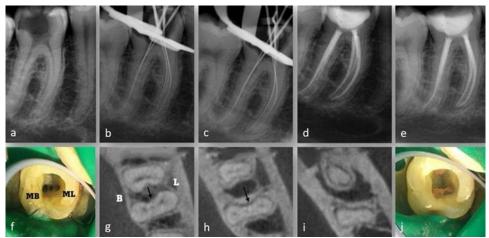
A midmesial canal in a mandibular first molar. (a) initial radiograph, (b,c) working length determination, (d,e) after filling, (f) canal orifices in mesial root, (g) coronal third- (black arrow shows midmesial canal), (h) middle third- (black arrow shows midmesial canal), (i) apical third-CBCT images, (j) canal orifices after filling.
